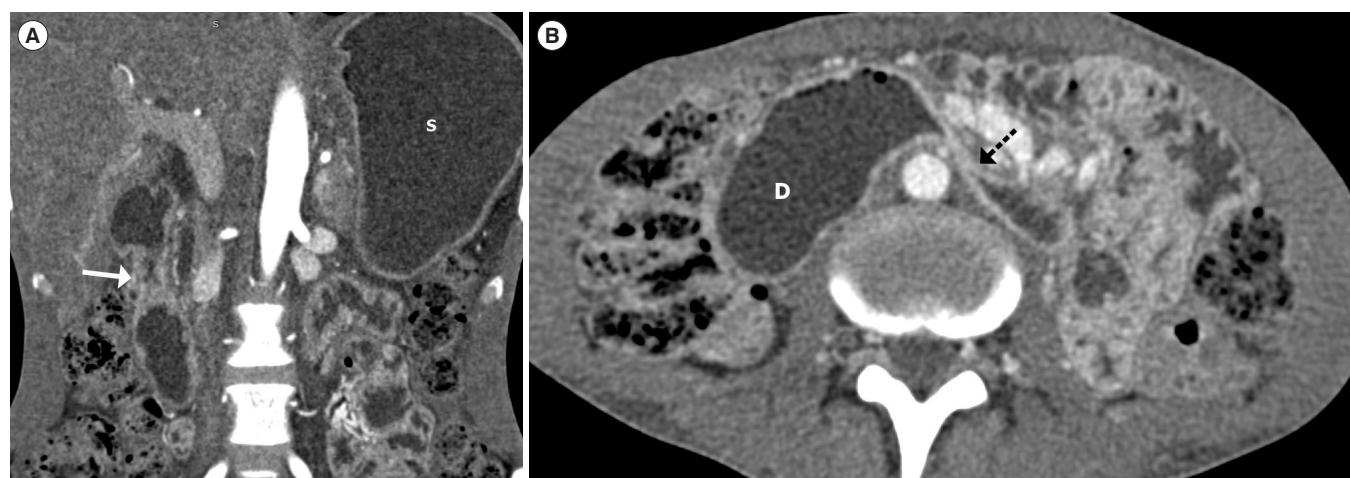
CT findings in a patient with opioid abuse gastroenteropathy. (A) Contrast-enhanced CT image showing dilated stomach secondary to narrowing and wall thickening in the D2 segment of duodenum (white arrow) in a 28-year-old patient with a history of long-term opioid abuse who presented with gastric outlet obstruction. (B) The same patient had another stricture at the junction of the D3-D4 segment (black dashed arrow) with upstream duodenal dilatation. S, stomach; D, duodenal.
